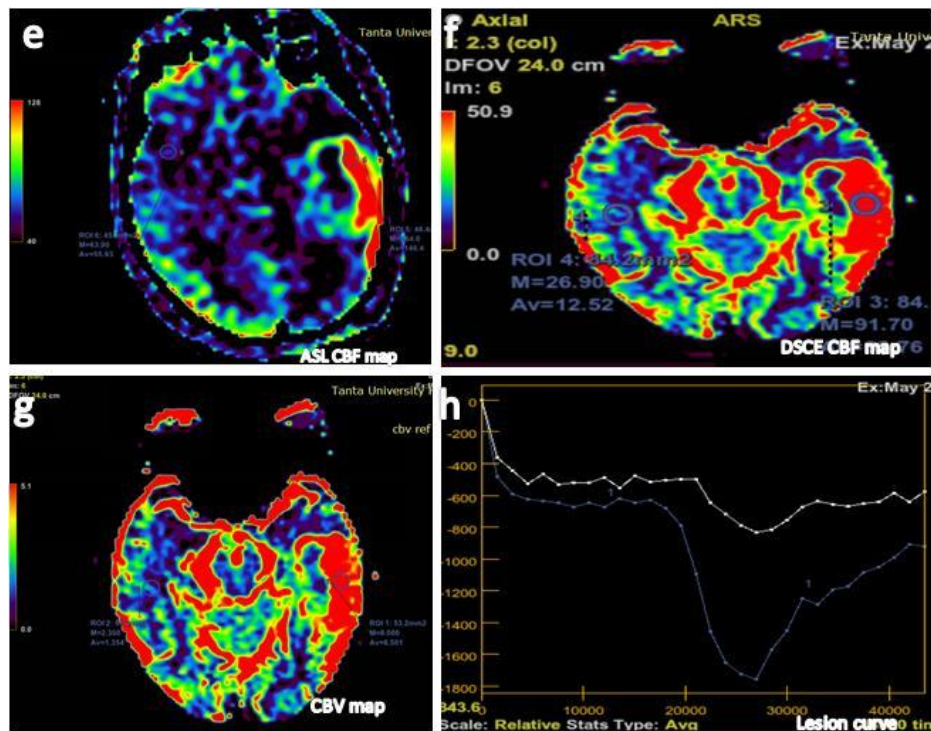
MRI of the brain(axial views) shows an ill -defined non-hemorrhagic intraaxial SOL in the left temporo-occipital lobes, displaying a low signal on T1WI , measuring about 5x4 x5 cm in its maximum dimensions with marginal uneven enhancement and central area of cystic degeneration (a,b) , high signal on T2WI and FLAIR sequence, being surrounded by a vasogenic edema and both exert mass effects in the form of effacement of overlying cortical sulci and compression of the temporal horn of left lateral ventricle(c,d). ASL and DSC color maps show marked hyperperfusion of the lesion mild extending to the peri-lesional area and hypoperfused its central necrotic part compared with the contralateral normal white matter. ASL r CBF=3.5, CBF absolute value = 160 ml/100 gm/min,DSC r CBF =3.5 , DSC CBF absolute value = 75 ml/100 gm/min , DSC rCBV = 3.4(e-g). The lesion signal to time curve shows rapid signal drop to baseline and rapid rise (blue curve in h).
